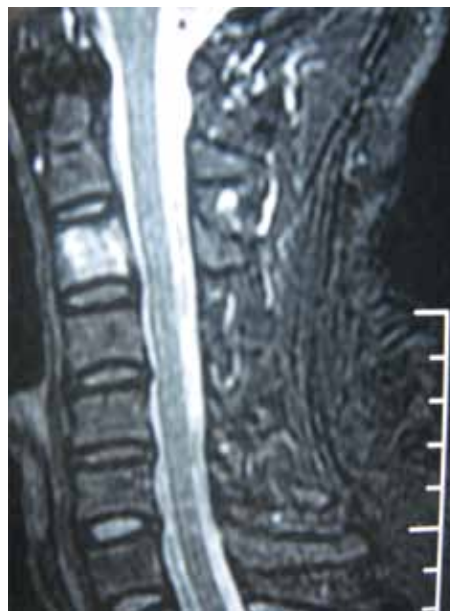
T2-weighted sagittal MRI showed well-distributed high signals.
